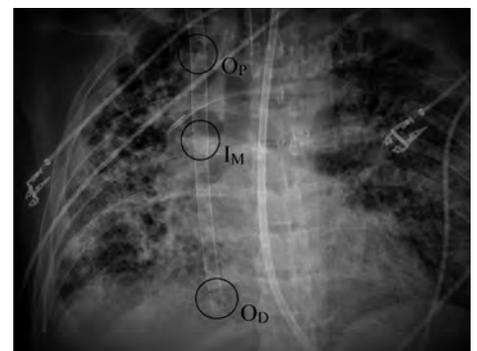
Post-deployment chest radiograph confirming adequate cannula position, with the distal outflow port (OD) resting within the inferior vena cava, the medial inflow port (IM) facing the tricuspid valve and the proximal outflow port (OP) situated in the superior vena cava
